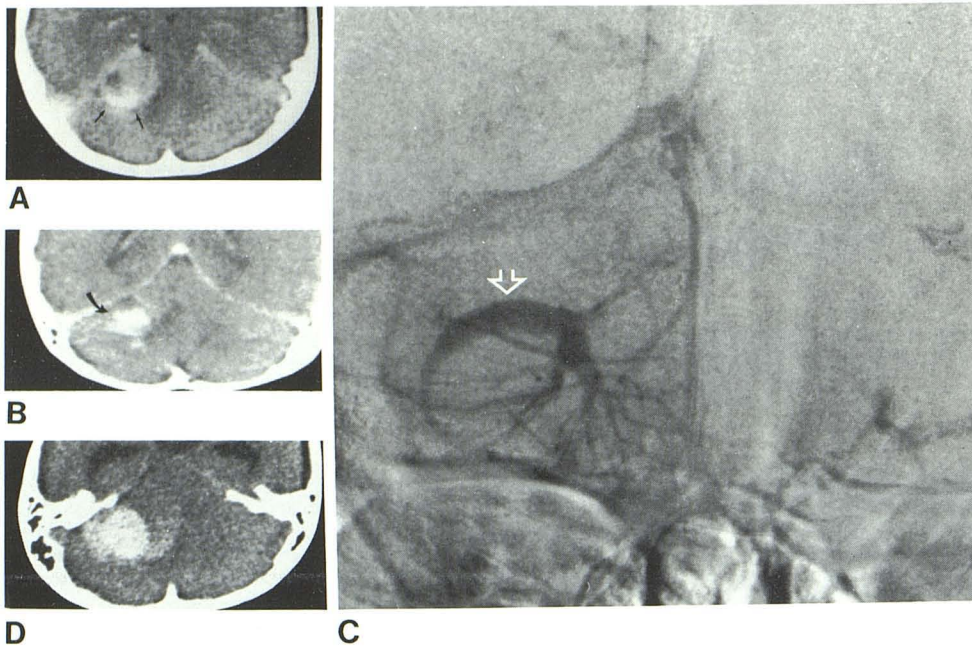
Case 1. A, Comma-shaped enhancing structure (arrows) in posterior part of right cerebellar hemisphere hematoma. B, Coronal scan shows structure runs horizontally across superior aspect of hematoma (arrow). C, Venous phase of vertebral angiogram. Enlarged medullary veins drain into large horizontal transcerebellar vein (arrow), which corresponds to density in A and B. D, Noncontrast CT scan 8 days after A and B shows dense acute hematoma near site of large transcerebellar vein. Note also development of hydrocephalus.
